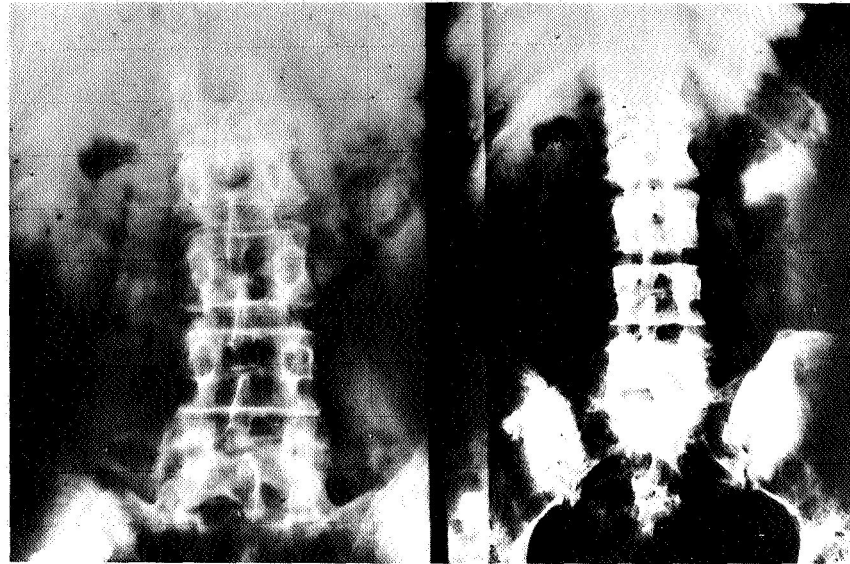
Roentgenographs of lumbar spine and pelvis of a 53-year-old female with osteoporosis (left) and after fluoride treatment (right).
